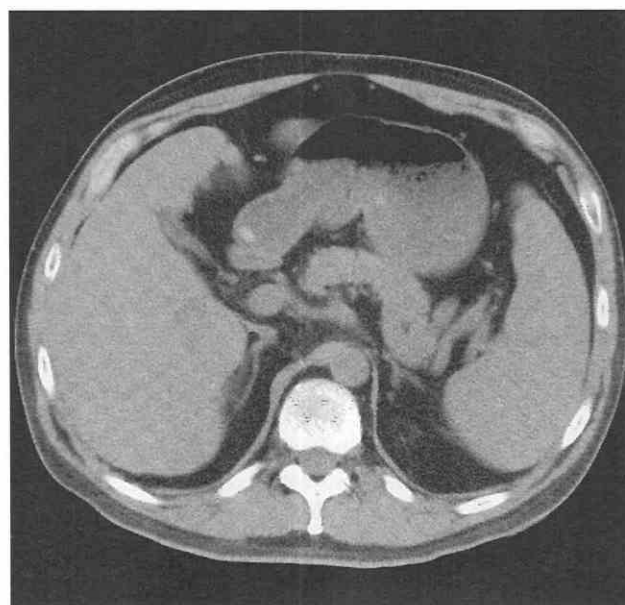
Thin-section axial CT scan showing neck of gallbladder.
